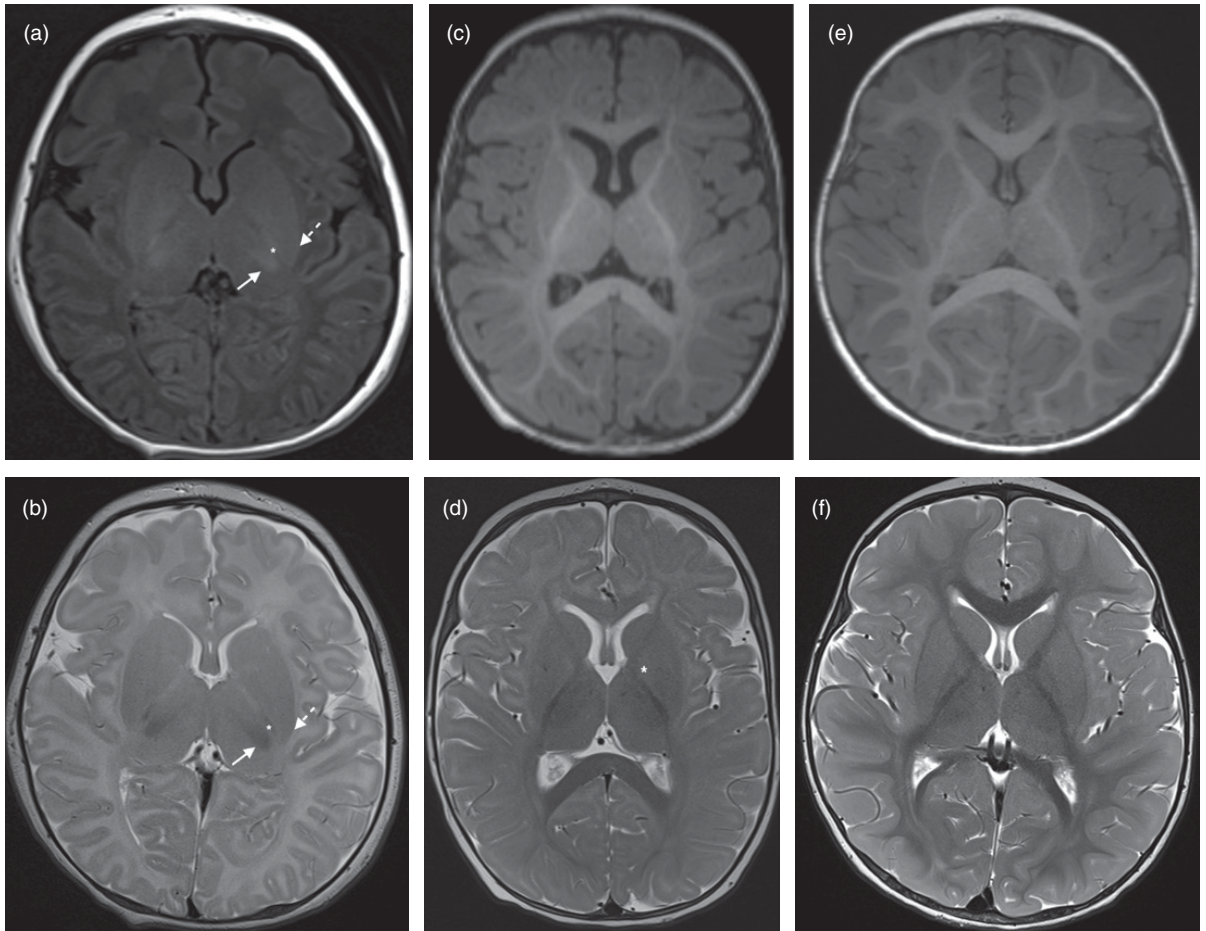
Normal brain myelination using T1-weighted (a, c, e) and T2-weighted (b, d, f) sequences. In the normal neonatal brain (a, b), there is T1 hyperintensity and T2 hypointensity from brain myelination at the ventrolateral thalamus (arrow with solid stem on the left), posterior putamen (arrow with dashed stem on the left), and posterior limb of the internal capsule (asterisk on the left). By 6 months of age (c, d), myelination is now visible out to the subcortical white matter throughout the brain on T1-weighted imaging but myelination on T2-weighted imaging is limited to the internal capsule and corpus callosum. Note relative T2 hyperintensity of the globus pallidus at this age (asterisk on the left in d). By 18 months of age (e, f), myelination has further matured in the subcortical white matter on T1-weighted imaging, and myelination on T2-weighted imaging has reached the subcortical white matter.
